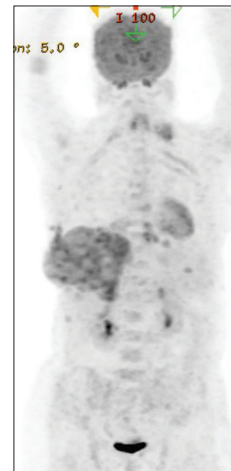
Positron emission tomography-computed tomography showing bulky FDG avid (SUV_{max} - 6.41) mass in the right lower back region with supradiaphragmatic adenopathy along with hypermetabolic nodular deposits in the anterior abdominal wall, right posterior chest walls, right elbow region, and paravertebral regions
